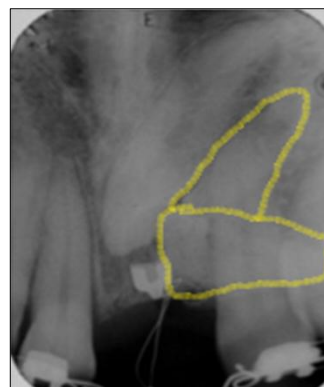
Critical inspection of peri apical radiograph
